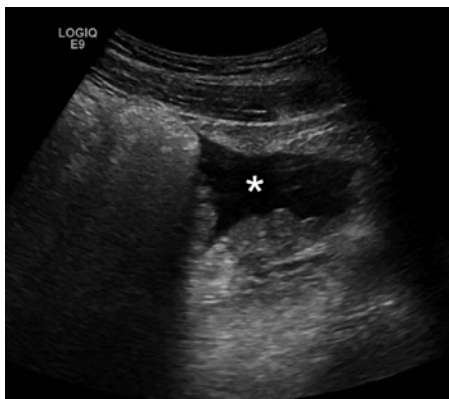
Focused assessment with sonography for trauma (FAST) scan. Transabdominal ultrasound reveals moderate complex free fluid in the right lower quadrant, indicated with an *asterisk* (\*), in a patient with a ruptured tubal ectopic pregnancy
